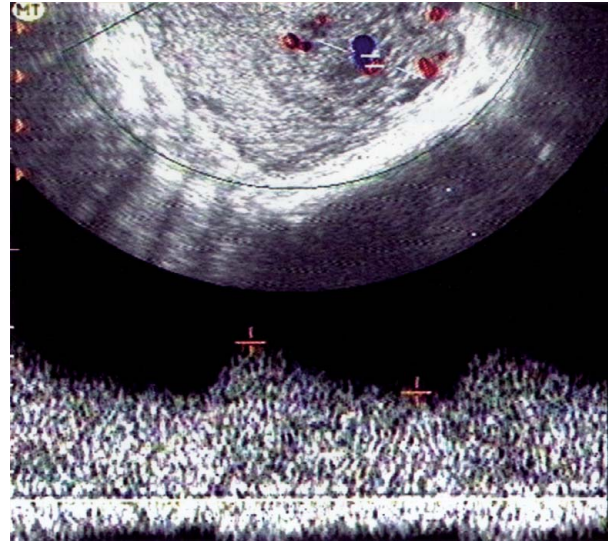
Endovaginal sonogram of the uterus with spectral Doppler tracing obtained within the uterine arteriovenous malformation. Note the characteristic high-velocity peak systolic flow with associated high diastolic flow and low-resistance pattern (resistance index, 0.32).
